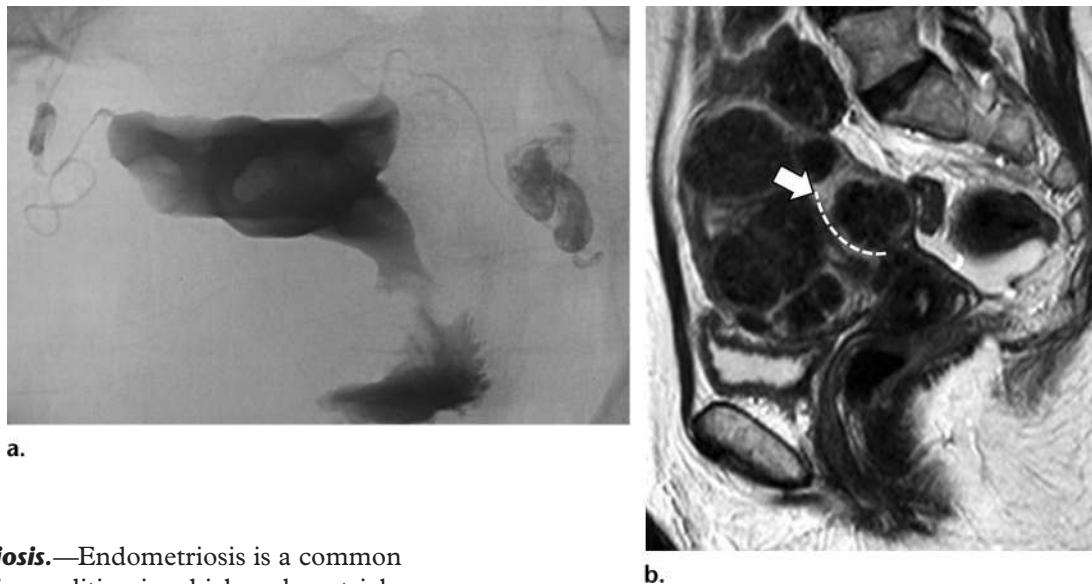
Multimodality imaging of fibroid burden in a 32-year-old woman. A combination of HSG and MR imaging is often used to guide fertility-restoring therapy. (a) En-face HSG image with a large FOV shows multiple filling defects of the uterine cavity but preserved distal filling of the tube. (b) Sagittal T2-weighted MR image confirms the HSG findings of multiple fibroids distorting the configuration of the uterine cavity (arrow, dashed line). MR imaging better demonstrates the dimensions of the fibroids, their locations, and their suitability for treatment.
